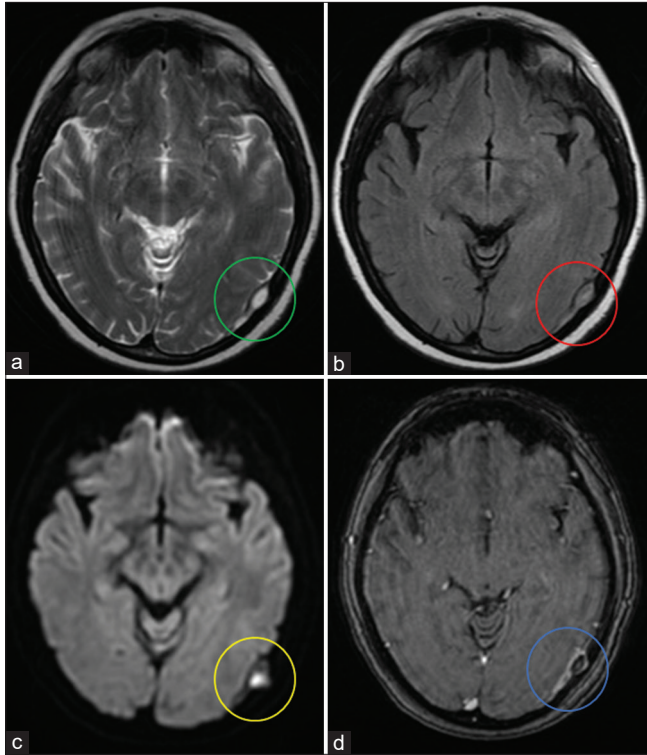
Brain magnetic resonance imaging sequences. In a (green circle), T2 weighted. In b (red circle), fluid attenuation imaging recovery acquisition (FLAIR). In c (yellow circle), diffusion-weighted sequence (DWI). In d (blue circle), gadolinium-enhanced T1 acquisition. One can see left parietooccipital subdural collection well demarked with hypersignal in T2 and intermediate signal in T2/FLAIR with water restriction to diffusion in DWI and peripheral enhancement after contrast.
